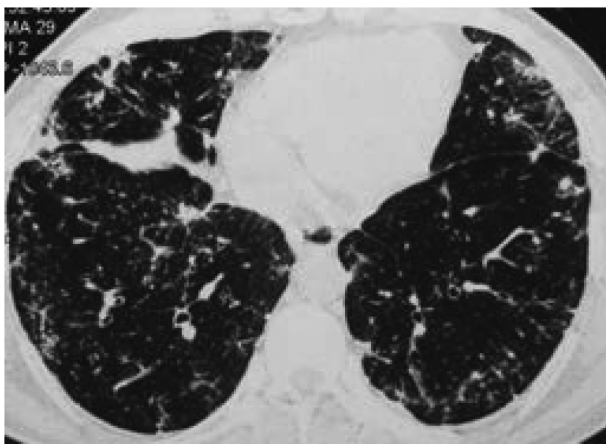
CT Thorax showing reticulonodular opacities with peribronchovascular distribution associated with traction bronchiectasis
